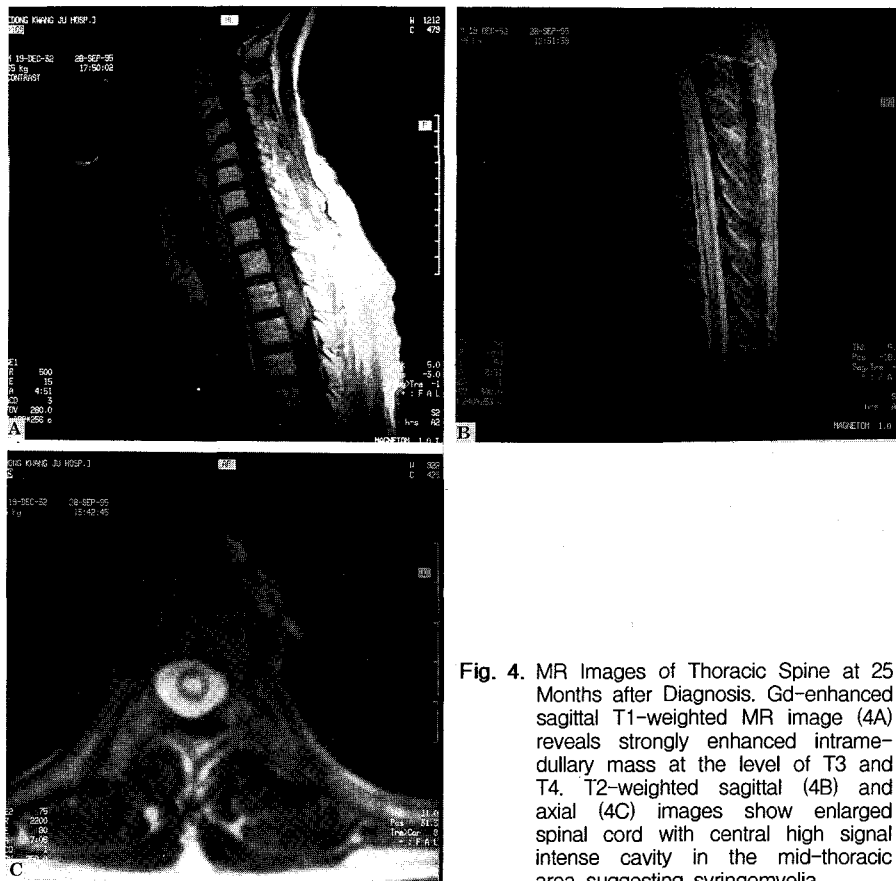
MR Images of Thoracic Spine at 25 Months after Diagnosis. Gd-enhanced sagittal T1-weighted MR image (4A) reveals strongly enhanced intramedullary mass at the level of T3 and T4. T2-weighted sagittal (4B) and axial (4C) images show enlarged spinal cord with central high signal intensity cavity in the mid-thoracic area suggesting syringomyelia.
